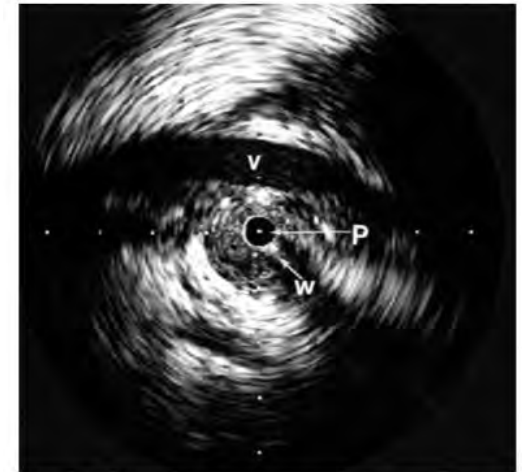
Endoluminal ultrasound image of anterior vessel crossing right UPJ. V, crossing vessel. P, ultrasound transducer. W, guide wire.
